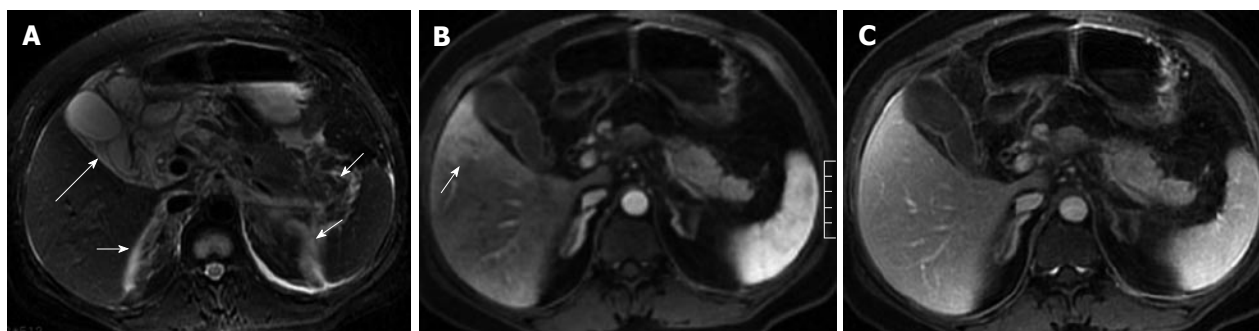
A 43-year-old woman with acute pancreatitis combined with cholecystitis. Respiratory-triggered axial fast recovery fast spin-echo T2-weighted image (A) shows the peripancreatic strand hyperintense signal and perinephric fluid collection (short arrow) as well as perigallbladder fluid (long arrow). Strip-shaped hepatic abnormal perfusion is found in the hepatic tissue adjacent to the gallbladder on the arterial phase images (B, arrow) and returns to normal on the venous phase images (C).
